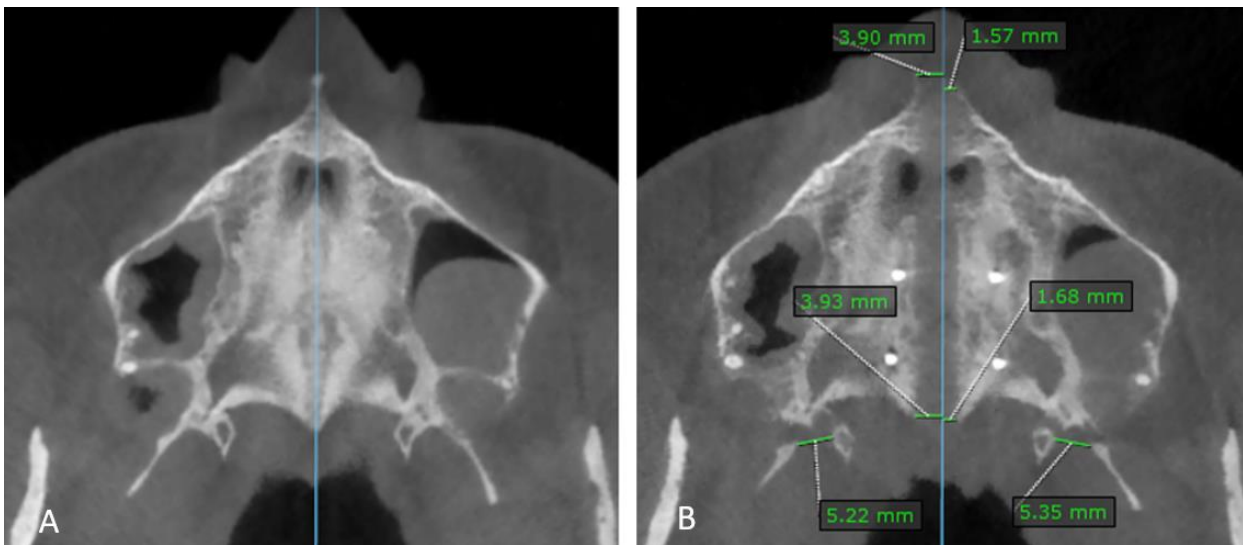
Measurements on the axial palatal section (APS). A: pre-expansion. B: post-expansion. Blue line: maxillary sagittal plane (MSP). MSP passes through ANS and PNS in the pre-expansion CBCT and becomes a reference line for measuring the lateral movements of skeletal landmarks in the post-expansion CBCT ^{36,44}.
